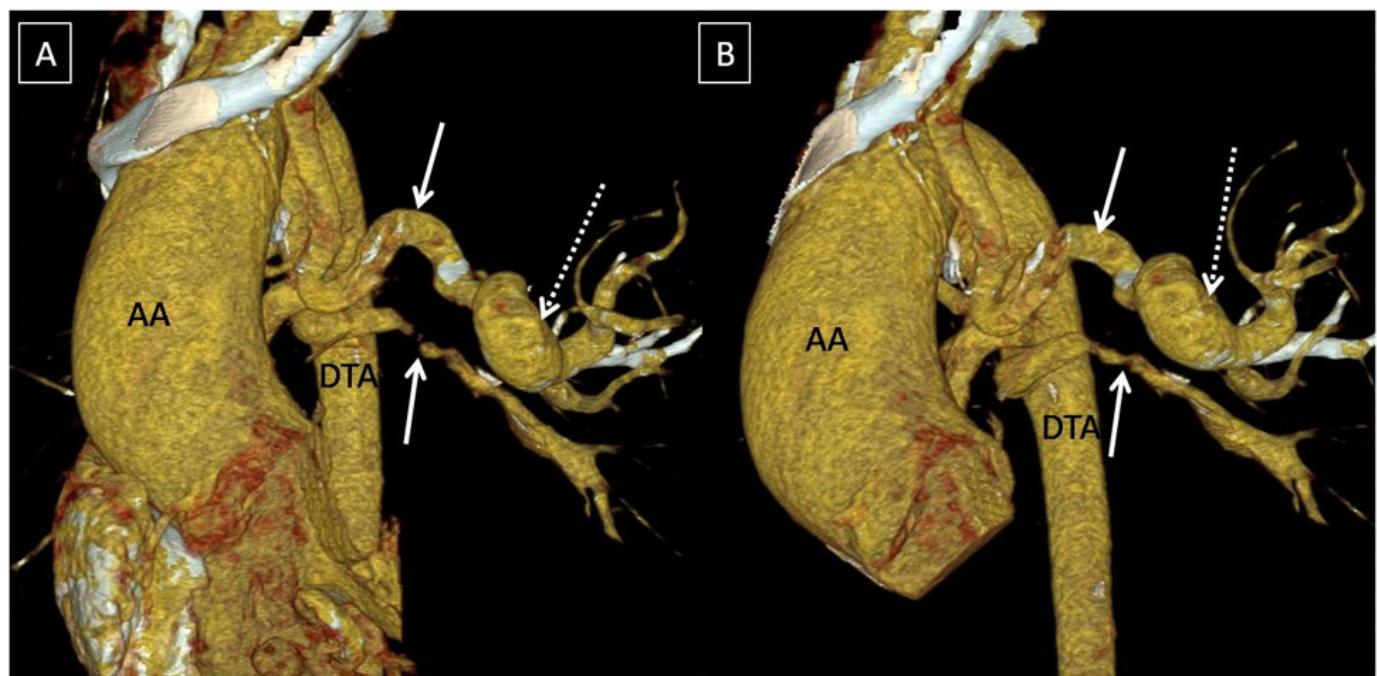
Volume rendered CT images nicely depicting the major aortopulmonary collateral arteries along with the aneurysm.
